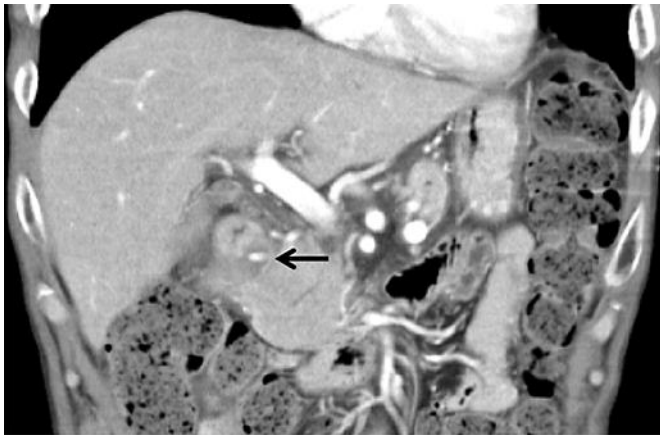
Contrast-enhanced computed tomography image showing a 2.2-cm ovoid low-density lesion with an enhanced vessel near the pancreatic head, suggesting pseudoaneurysm.
